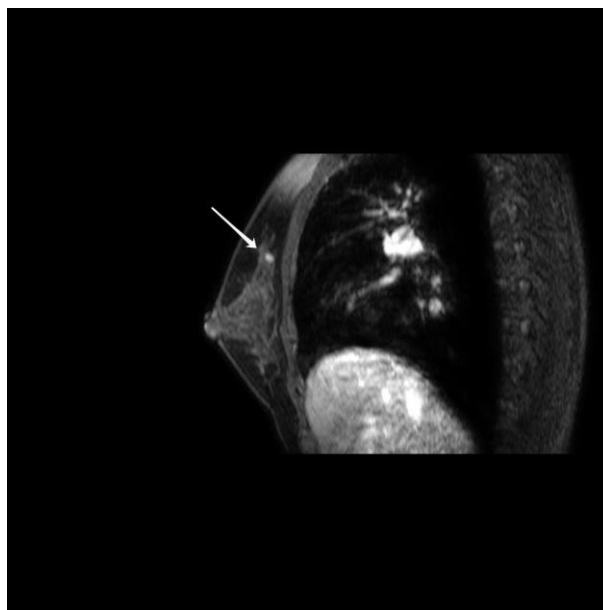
A contrast enhanced MRI suggesting a small mass (arrow).
